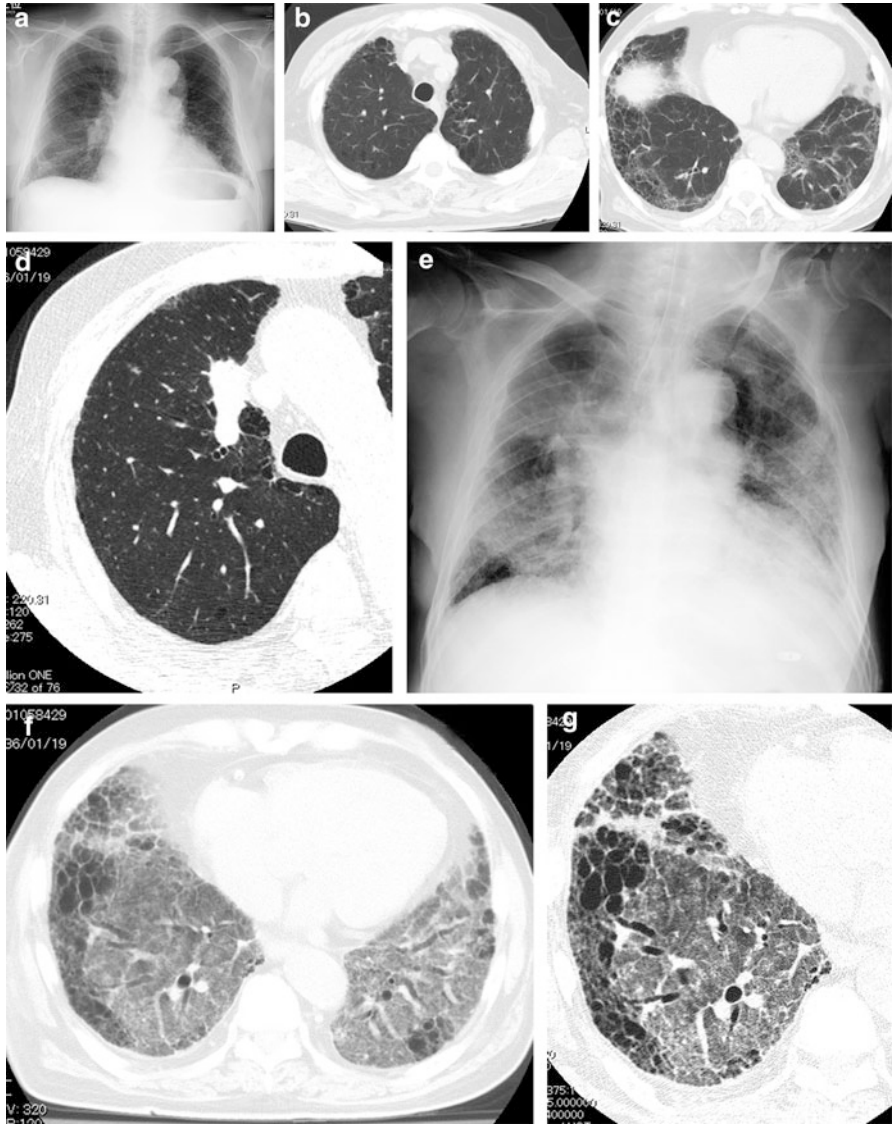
Postsurgical exacerbation of chronic fibrosing interstitial pneumonia with lung cancer. (a) Preoperative chest x-ray shows reticular opacity located predominantly in the bilateral lower lungs. The mass lesion is overlapped on the upper portion of the right hilum. (b) Computed tomography (CT) at the level of the upper lungs shows minimal emphysema. (c) CT at the level of the lung base shows reticular opacity and honeycomb lung in the subpleural regions. (d) High-resolution computed tomography (HRCT) of the right upper lobe shows nodular opacity, which is diagnosed as lung cancer by bronchoscopy. (e) Chest x-ray 4 days after right upper lobectomy shows widespread ground-glass opacity (GGO) and consolidation in bilateral lungs. (f) CT of the lower lungs shows diffuse GGO in the lungs. (g) HRCT of the right lower lobe shows diffuse GGO overlapping pre-existing interstitial pneumonia
